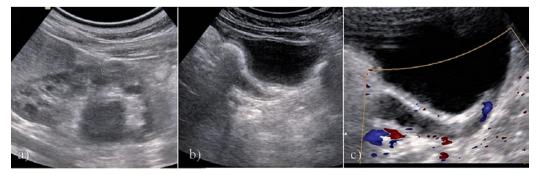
Case 5: a) Left kidney US, longitudinal scan: CS duplication with dilatation of the lower pelvicalicealsystem, reduced lower moiety parenchyma and a normal US aspect of the upper moiety; b) Longitudinal scan of the left vesicoureteral junction: ureteral dilatation (diameter of 7 mm) and ureteral wall thickening; c) Color Doppler interrogation of the left vesico-ureteral junction revealed retrograde flow from the bladder into the ureter (VUR).
